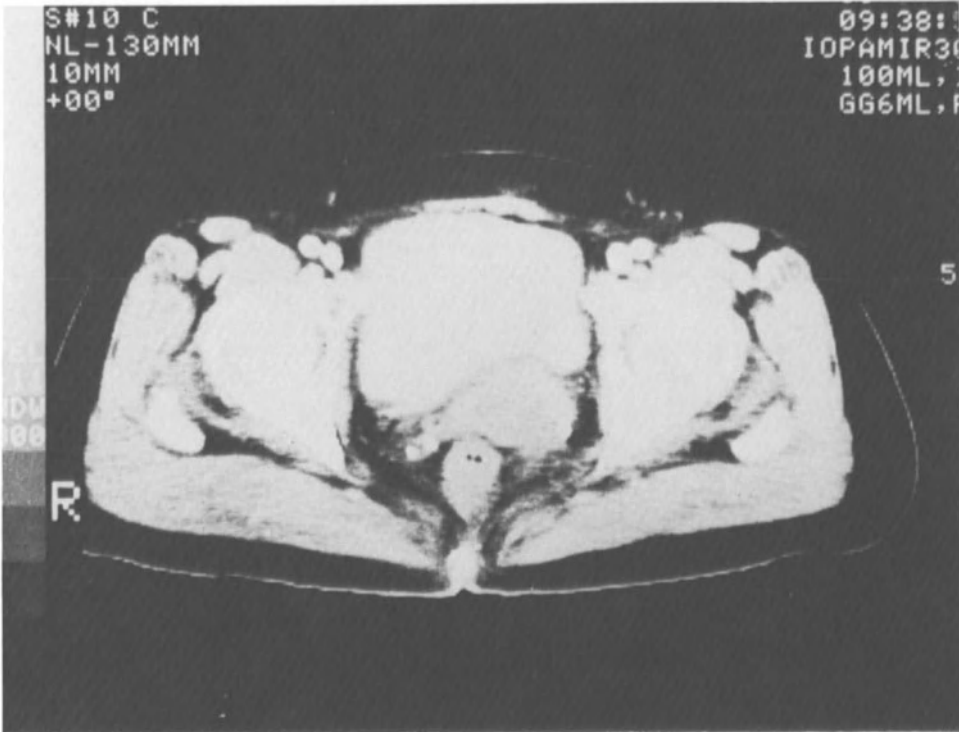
CT scan of Case No. 3 showing a recurrent rectal carcinoma, before thermoradiotherapy (M. Takehi, et al., 89).
